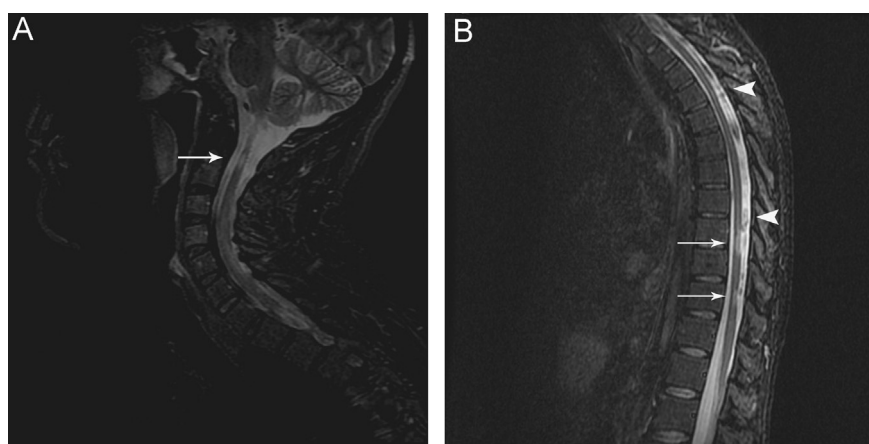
Spinal Cord MRI. (A) Sagittal Short T1 inversion recovery (STIR) of the cervical spinal cord shows a small hyperintense lesion at the C2 level (arrow). (B) Sagittal STIR of the thoracic spine shows two hyperintense lesions, the first at the T9-T10 level and the second at the T11 level (arrows). Spinal cord atrophy is also present (arrowheads).
